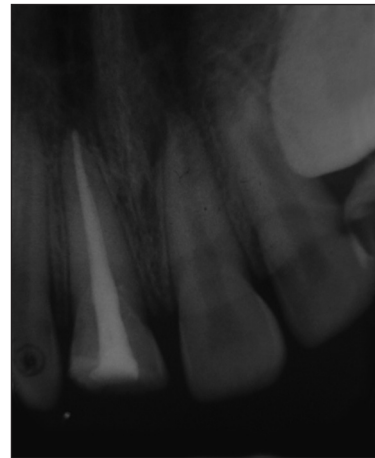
Intraoral periapical radiograph after root canal treatment
